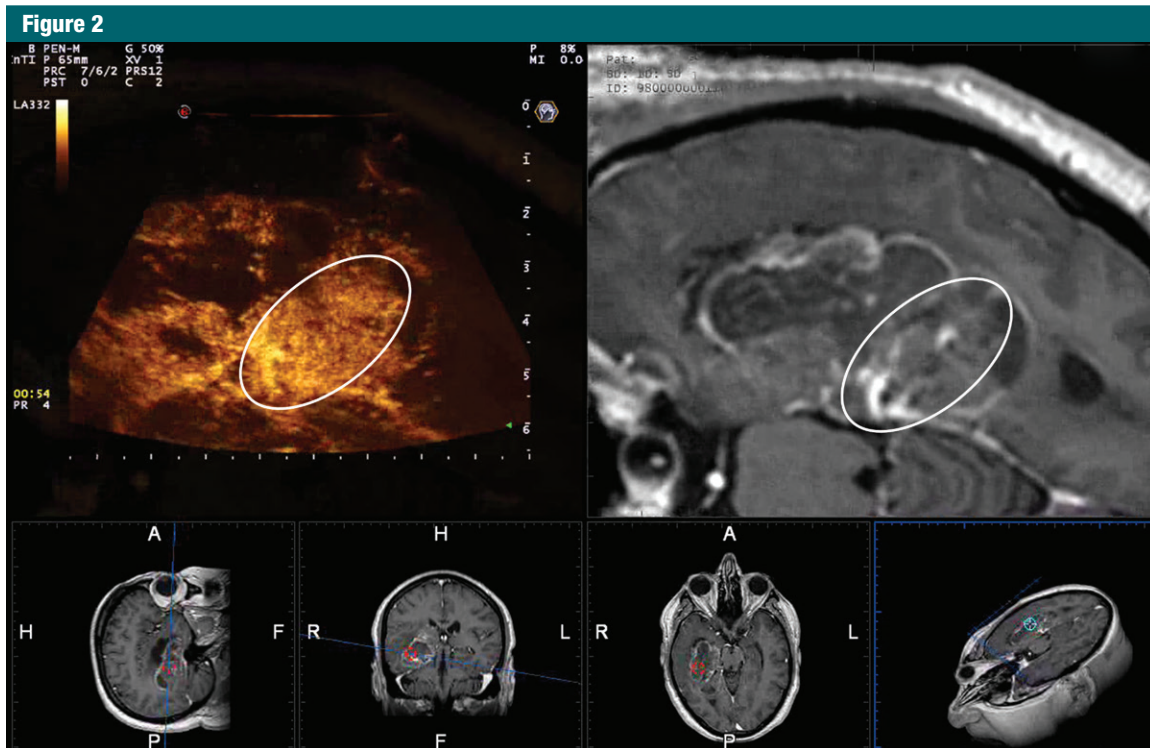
Screenshot of navigation contrast-enhanced US scan of left temporal GBM in 65-year-old man. Top row, contrast-enhanced US scan (left) and corresponding coplanar preoperative MR image (right). Oval indicates area with different enhancement on contrast-enhanced US scan and preoperative MR image. Bottom row, four reconstructions of preoperative MR images. Contrast-enhanced US scan demonstrates more intense contrast enhancement compared with gadolinium-enhanced T1-weighted MR image. Moreover, enhancement pattern differs. Gadolinium-enhanced T1-weighted MR imaging depicts large necrotic area surrounded by a ring-shaped solid tumor, whereas contrast-enhanced US demonstrates the part of the tumor that is extremely viable (oval). Intraoperative findings showed that this was solid tumor.
